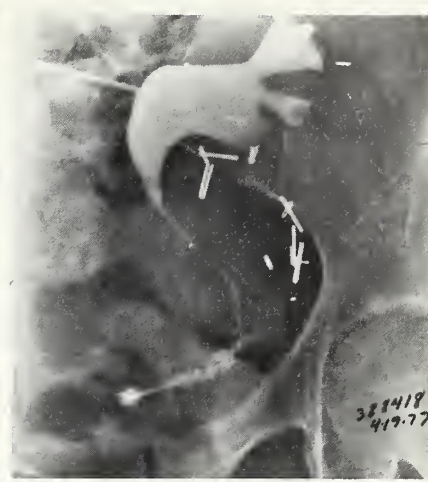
Antegrade pyelogram performed with ultrasound showing ureteral extravasation.
